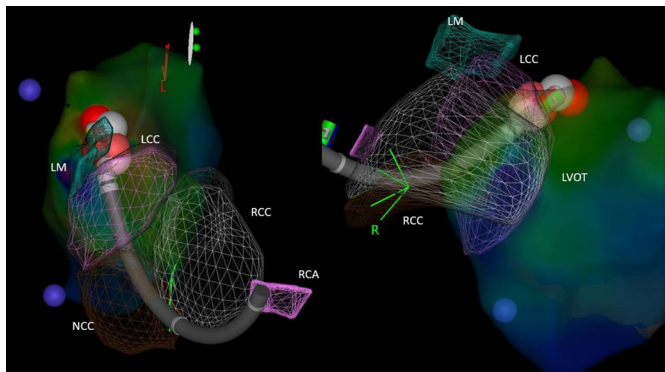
Electroanatomic maps of activation points and ablation with Cartosound contours of coronary cusps and coronary arteries in two projections: cranial view (left) and septal view (right). Purple spheres are mitral annular locations seen on ultrasound. Ablation lesions are in the left ventricular outflow tract below the coronary cusps. The proximal shaft of the catheter can be seen between the right coronary cusp and noncoronary cusp in proximity to the anatomic location of the membranous septum and branching portion of bundle of His. The 81 cm SL-1 sheath was not advanced beyond the aortic root. LCC indicates left coronary cusp; LM, left main artery; LVOT, left ventricular outflow tract; NCC, noncoronary cusp; RCA, right coronary artery; RCC, right coronary cusp.
